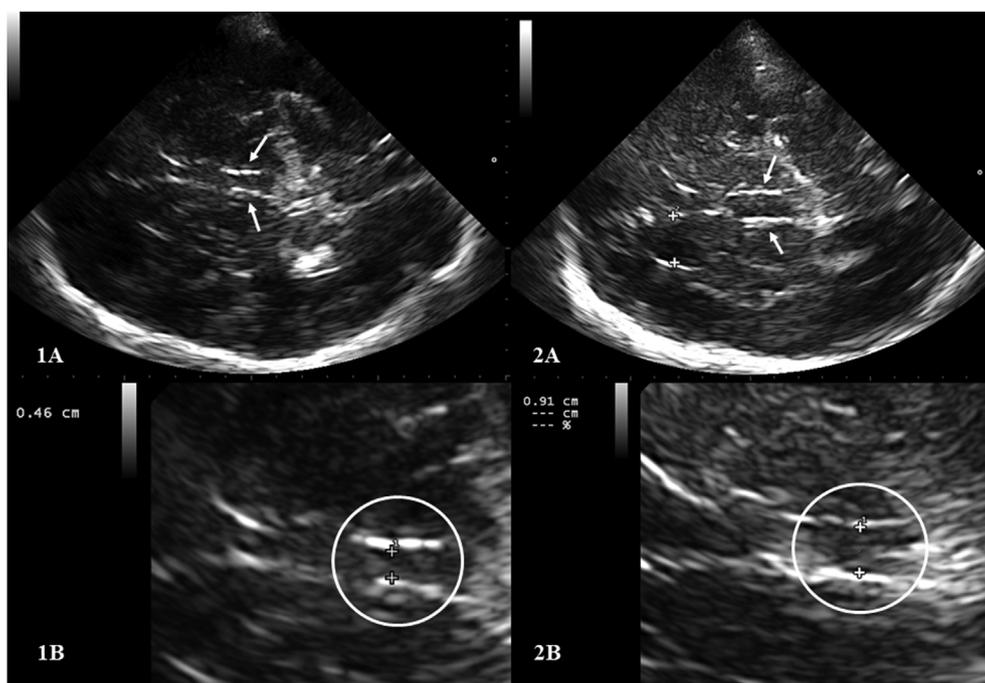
Sonographic assessment of the third ventricular width in two examples. 1A and 1B show a normal width of 4.6 mm. 1A = imaging of both hyperechogenic transition lines between ependyme and cerebrospinal fluid in the center of the image (arrows) being the sonographic aspect of the third ventricle. 1B = measurement of the distance between the inner boundaries after enlarging the sonographic image of the third ventricle (circle) with the zoom-function. 2A and 2B show an enlarged third ventricle with a width of 9.1 mm in the overview (2A) and in the zoomed image (2B).
